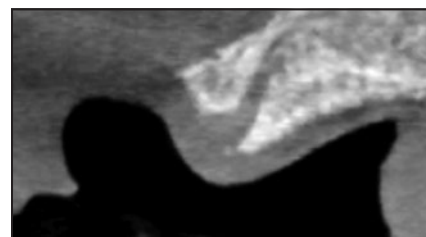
Calibration of STL files over the CT image is done by following the soft tissue outline.
